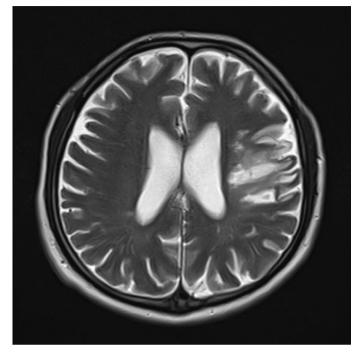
Preoperative cranial MRI image *MRI: Magnetic resonance imaging*
